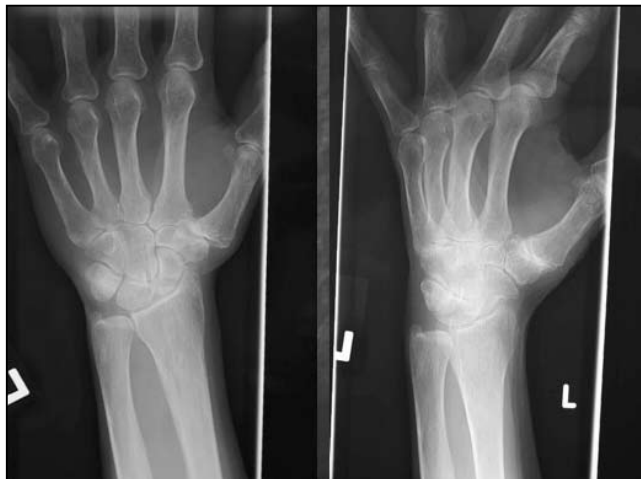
Radiographic appearance of osteoarthritis of the thumb carpometacarpal joint.
